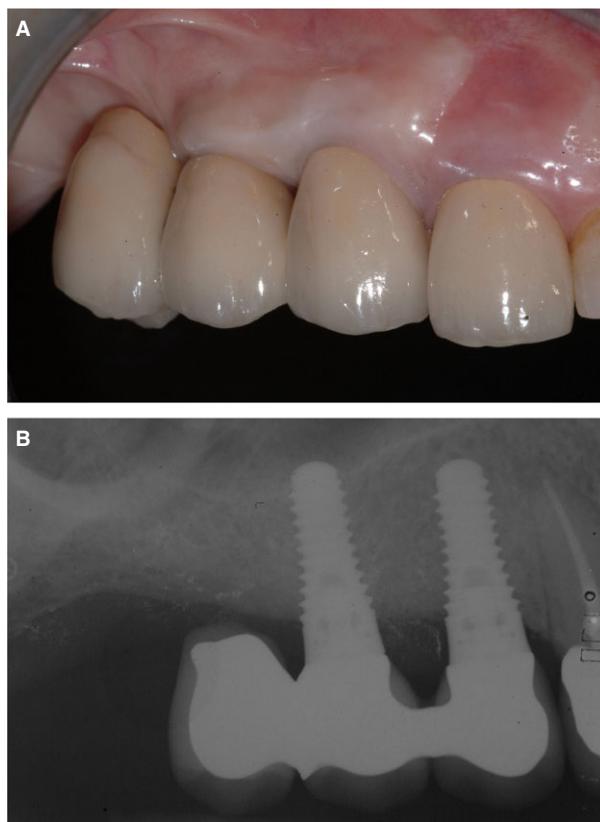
Clinical (A) and radiographic (B) appearance of the treated area after rehabilitation. (Prosthetic rehabilitation, Dr Paolo Casentini.)
